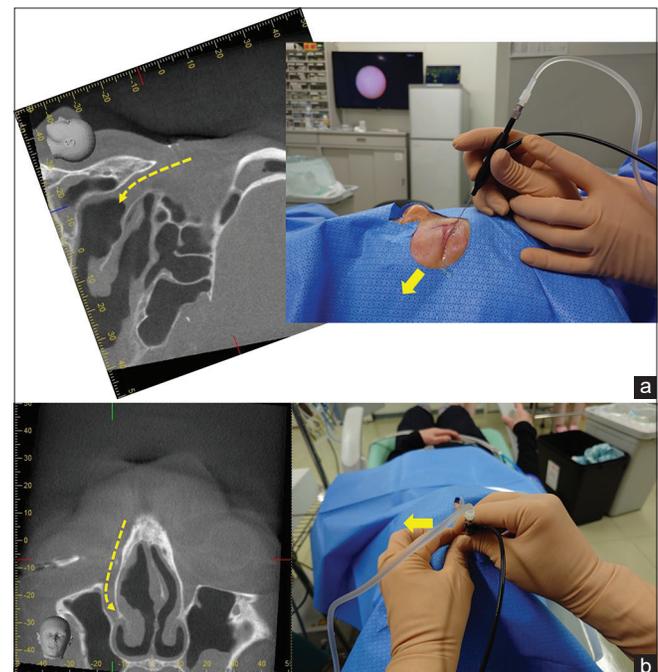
Finger control of the endoscope handpiece. The surgeon's finger control of the handpiece (e.g., angular modulation and rotation) enables precise adjustment of the endoscope probe trajectory in response to anatomical variations of the nasolacrimal duct (NLD). (a) Posterior-type NLD (dotted yellow arrow) on computed tomography (CT). The handpiece is held in an upright position to accommodate the posterior inclination of the NLD. The probe tip is directed posteriorly (solid yellow arrow). (b) Inward-type NLD (dotted yellow arrow) on CT. The handpiece is held in a counterclockwise position to accommodate the inward inclination of the NLD. The positioning of the image guide cable suggests an inward trajectory of the probe tip (solid yellow arrow)
